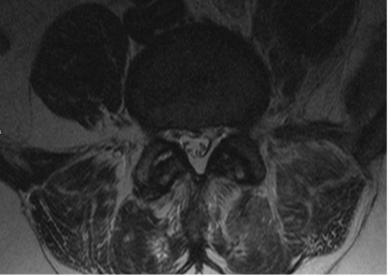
Sagittal and axial MRI images showing no evidence of discitis, only degenerative changes in L5-S1 disc.
